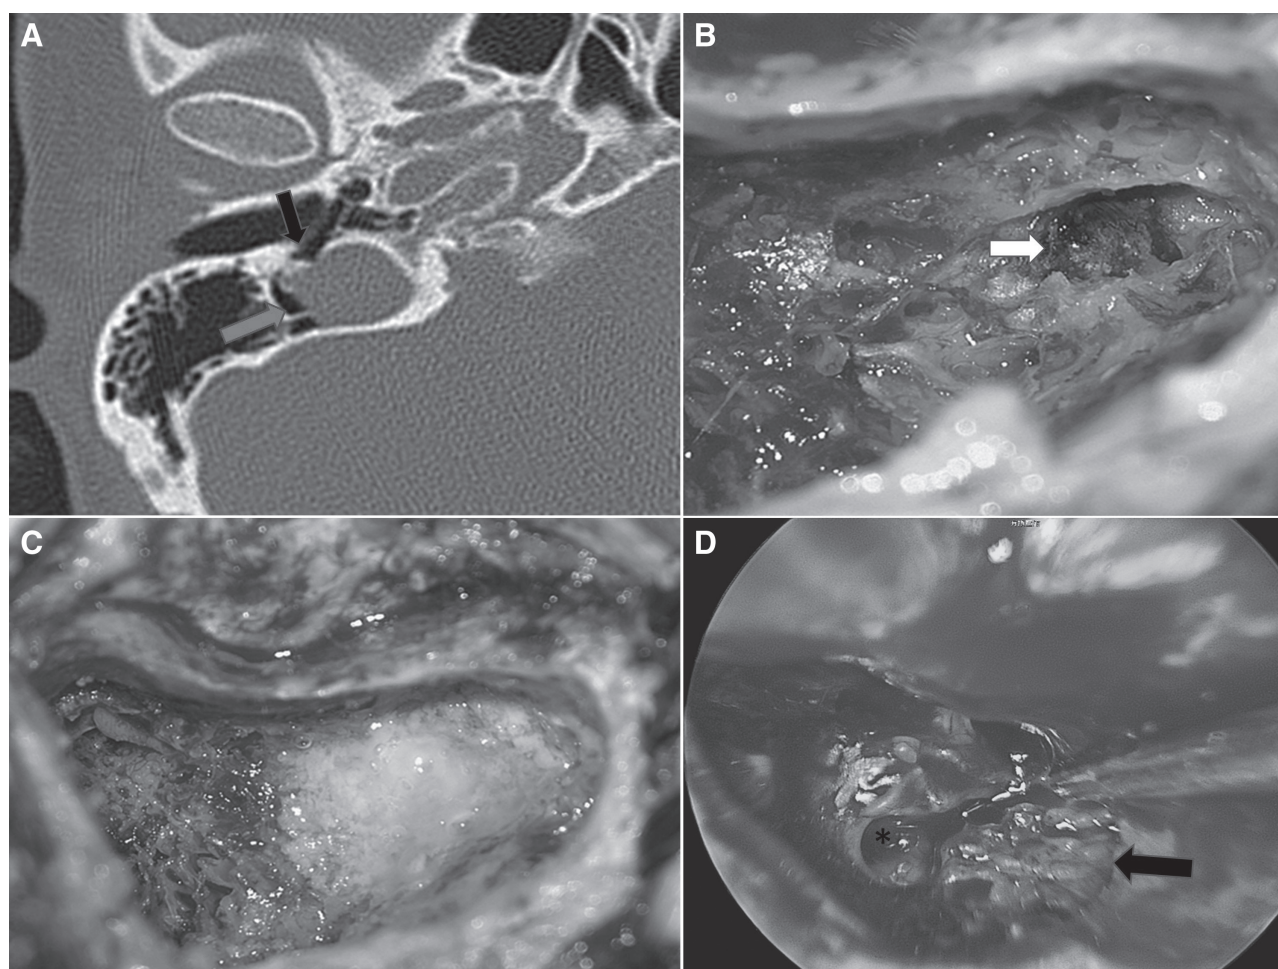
A, Computed tomography of temporal bone (case no. 11) showed jugular bulb dehiscence over mastoid (red arrow) and hypotympanum (black arrow). B, Jugular bulb dehiscence noted under exoscope (white arrow). C, After resurfacing of the dehiscence. D, Endoscopic view of dehiscence over hypotympanum (black arrow). *: round window.
